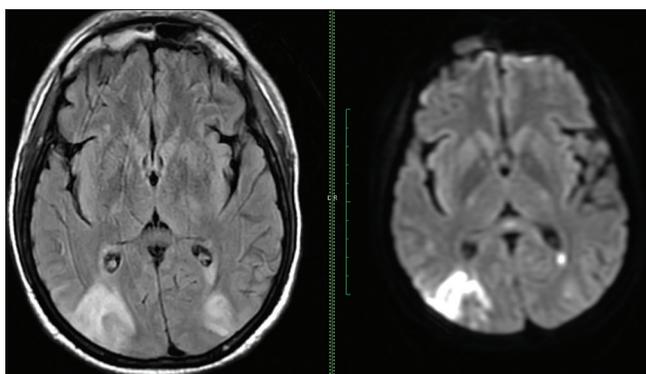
Magnetic resonance imaging shows diffusion-weighted imaging restrictions in the right parieto-occipital lobe suggesting acute infarct
